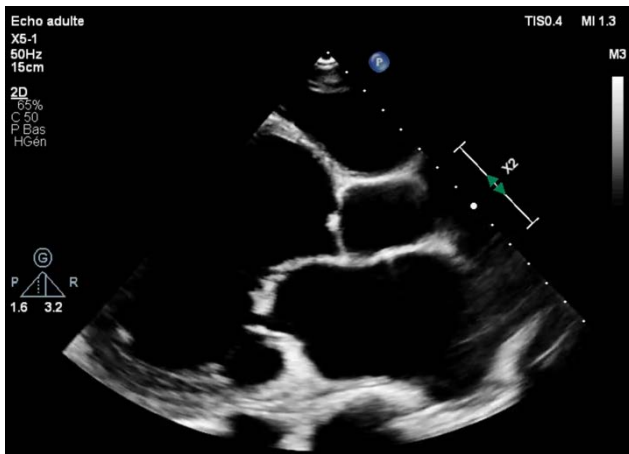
Parasternal long-axis 2D view showing advanced LV dysfunction and structural valve degeneration Parasternal long-axis view showing severe LV systolic dysfunction with wall thinning, leaflet thickening, posterior leaflet restriction with mild anterior prolapse, and a wide coaptation defect consistent with advanced degenerative mitral regurgitation
